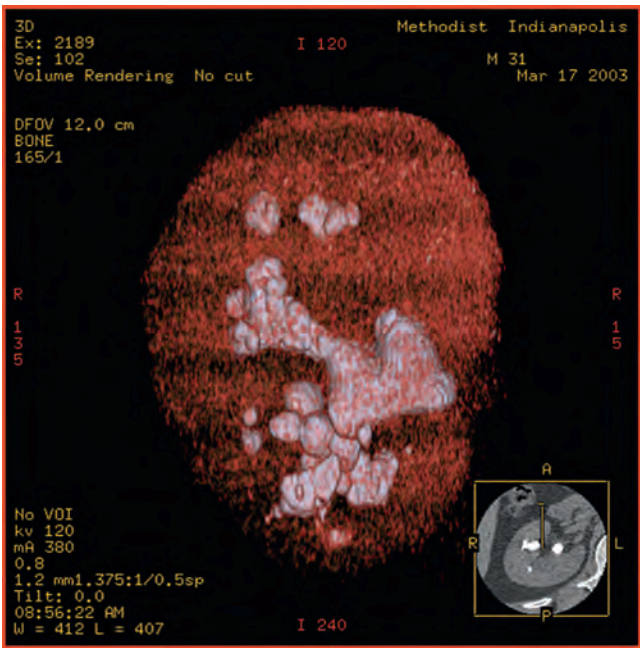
Three-dimensional computed tomography reconstructed image of a staghorn calculus.
